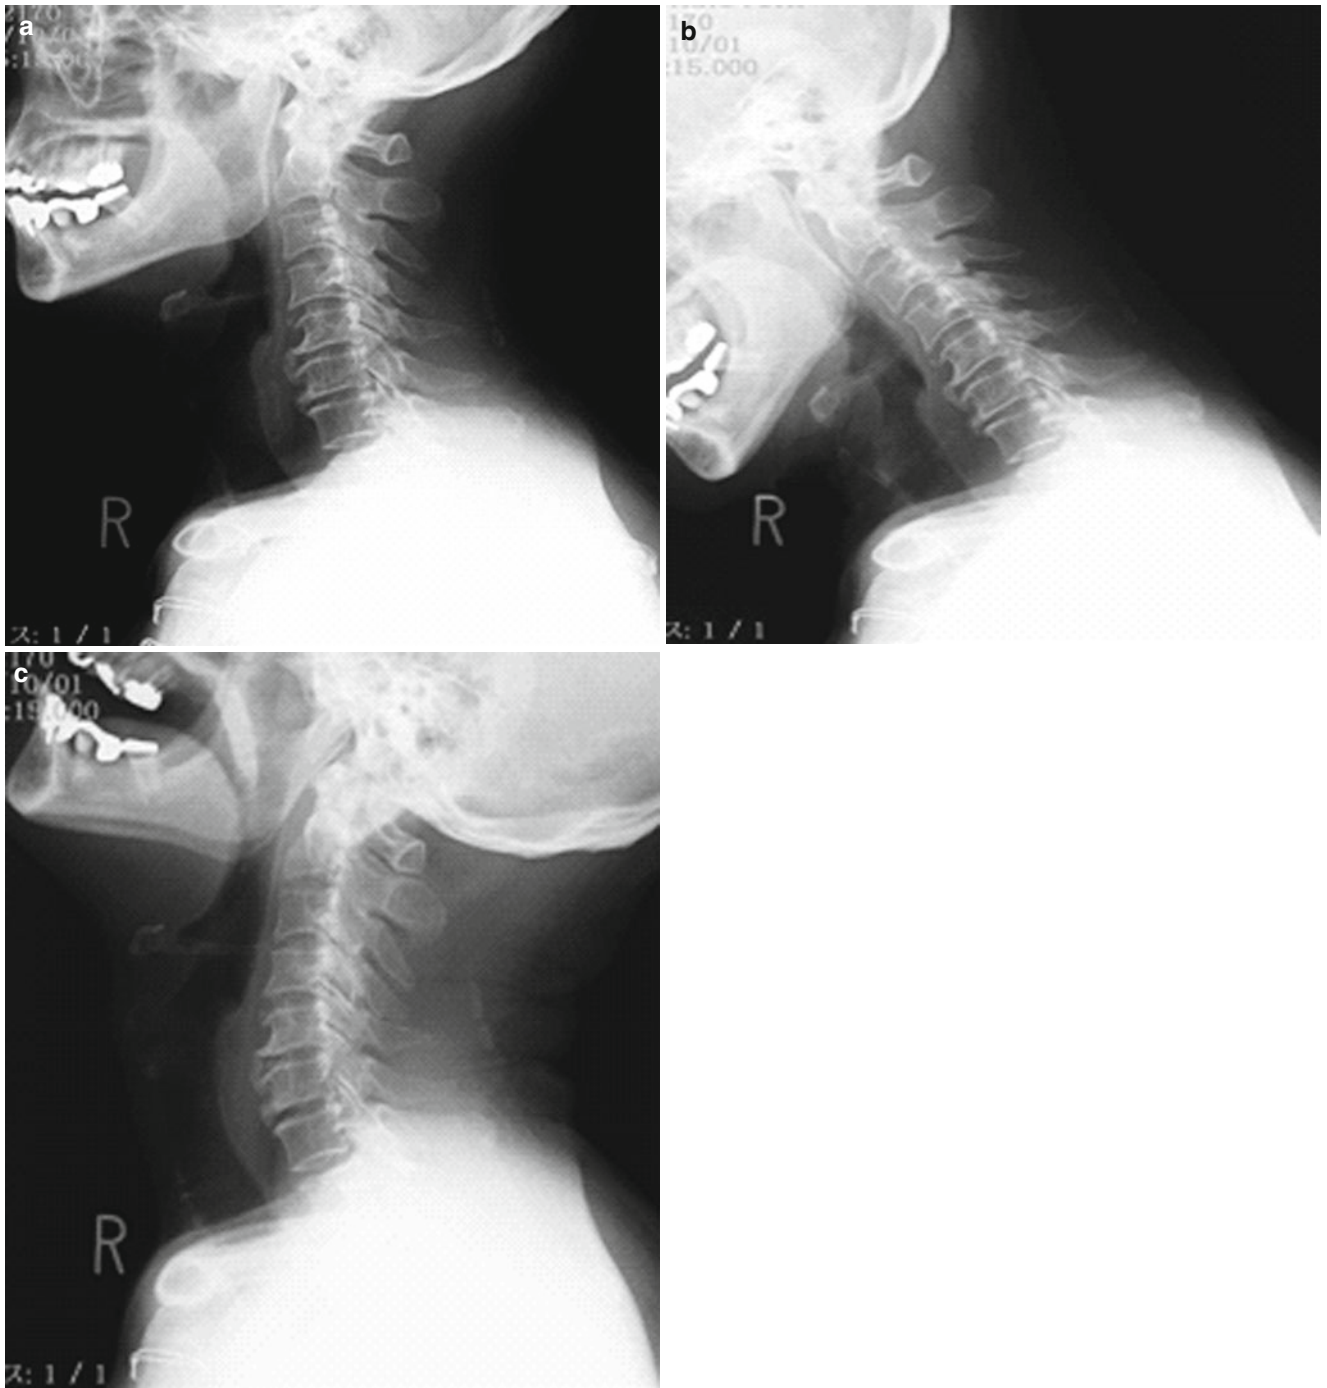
Skip laminectomy. (a–c) Preoperative cervical radiographs
